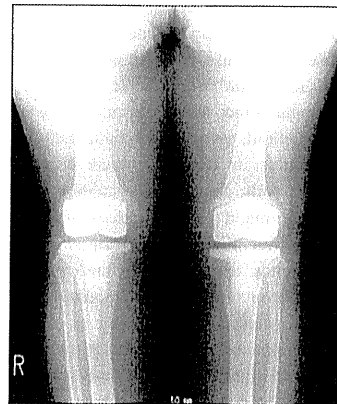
AP radiograph did not show the tumor at the lateral side of the implant of the left knee.
